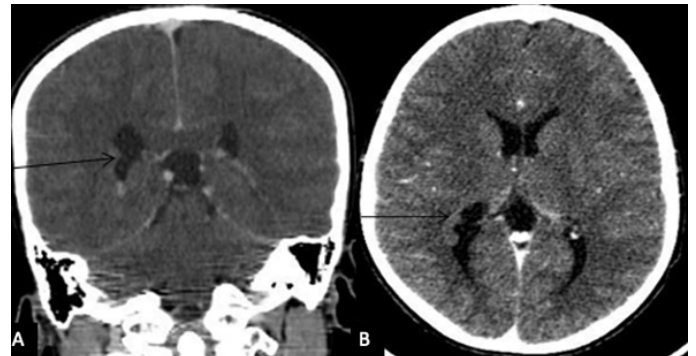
1A & B) Young child of 05 years old, admitted for chronic headaches, with the presence of periventricular nodular lesions of the same density of the cortex on the CT scan.
